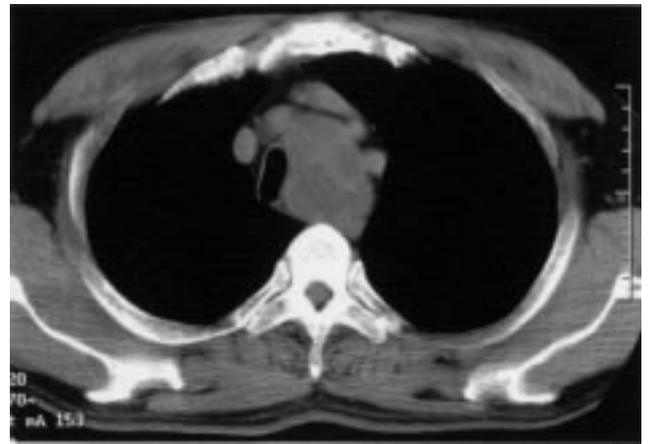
Chest computed tomography showed a large mass in the superior mediastinum extending to the aortic arch. The trachea was compressed laterally, and proximal brachial cephalic arteries were displaced.
